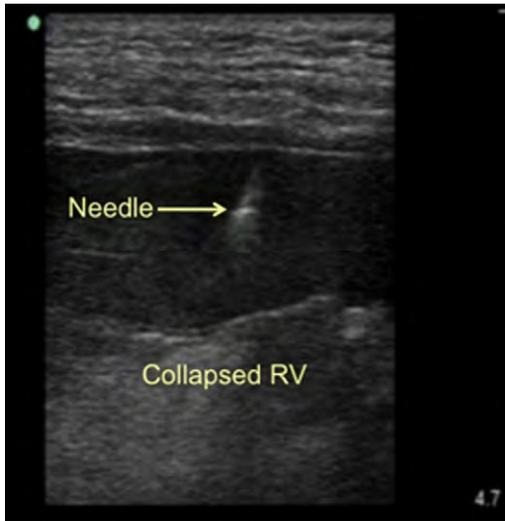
Pericardiocentesis using ultrasound guidance with a high-frequency linear array transducer. RV, right ventricle.
